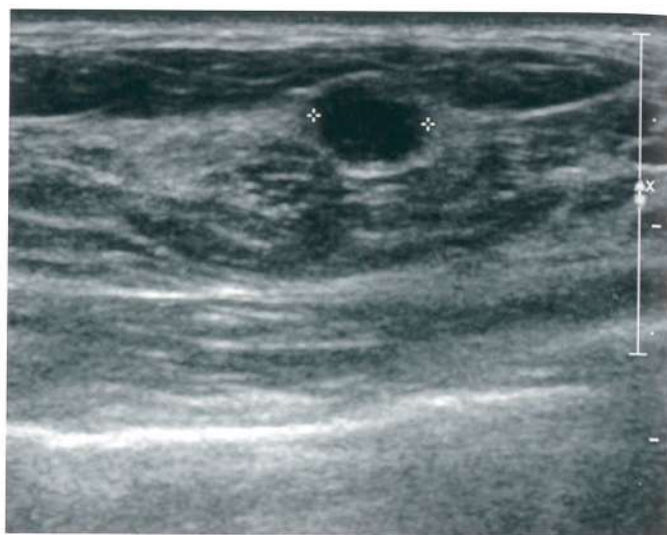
Ultrasound of an adenoid-cystic carcinoma. This small lesion was initially considered benign based on radiological findings and turned out to be an adenoid-cystic carcinoma on the following cytological and pathological examination. On ultrasound, it appears as an ovoid, hypoechoic, partially cystic mass with round contours and the long axis parallel to the skin.
